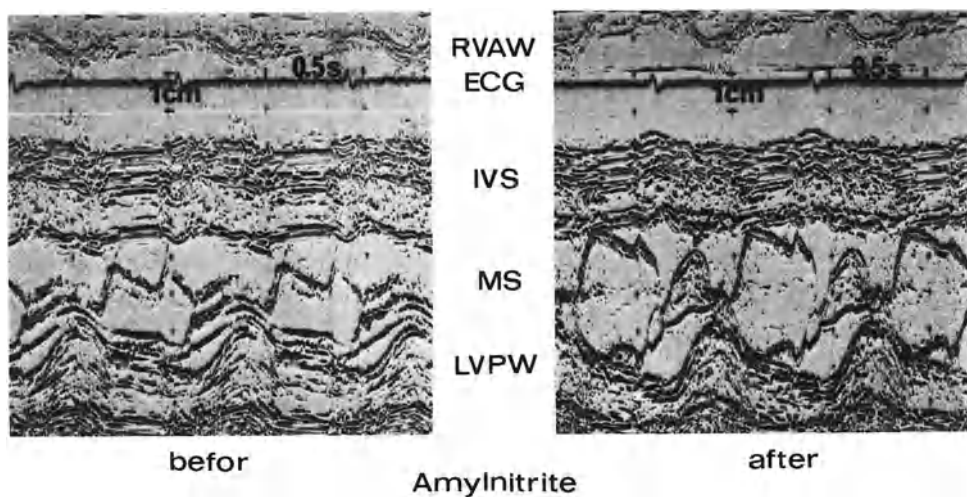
Echocardiogram of a patient with malignant arterial hypertension. Note the asymmetrical septum hypertrophy with a reduced systolic motion pattern. After application of amylnitrite a sharp systolic anterior motion (SAM) of the anterior mitral leaflet can be documented as a sign of provocative subvalvular outflow obstruction. From the echocardiogram alone no decision can be made concerning the etiology of the ASH, whether myopathic or nonmyopathic
